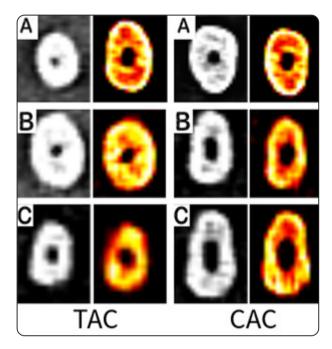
Representative CBCT images of axial view for TAC and CAC to evaluate transportation before and after instrumentation at 3 (A), 6 (B) and 9 mm (C).
